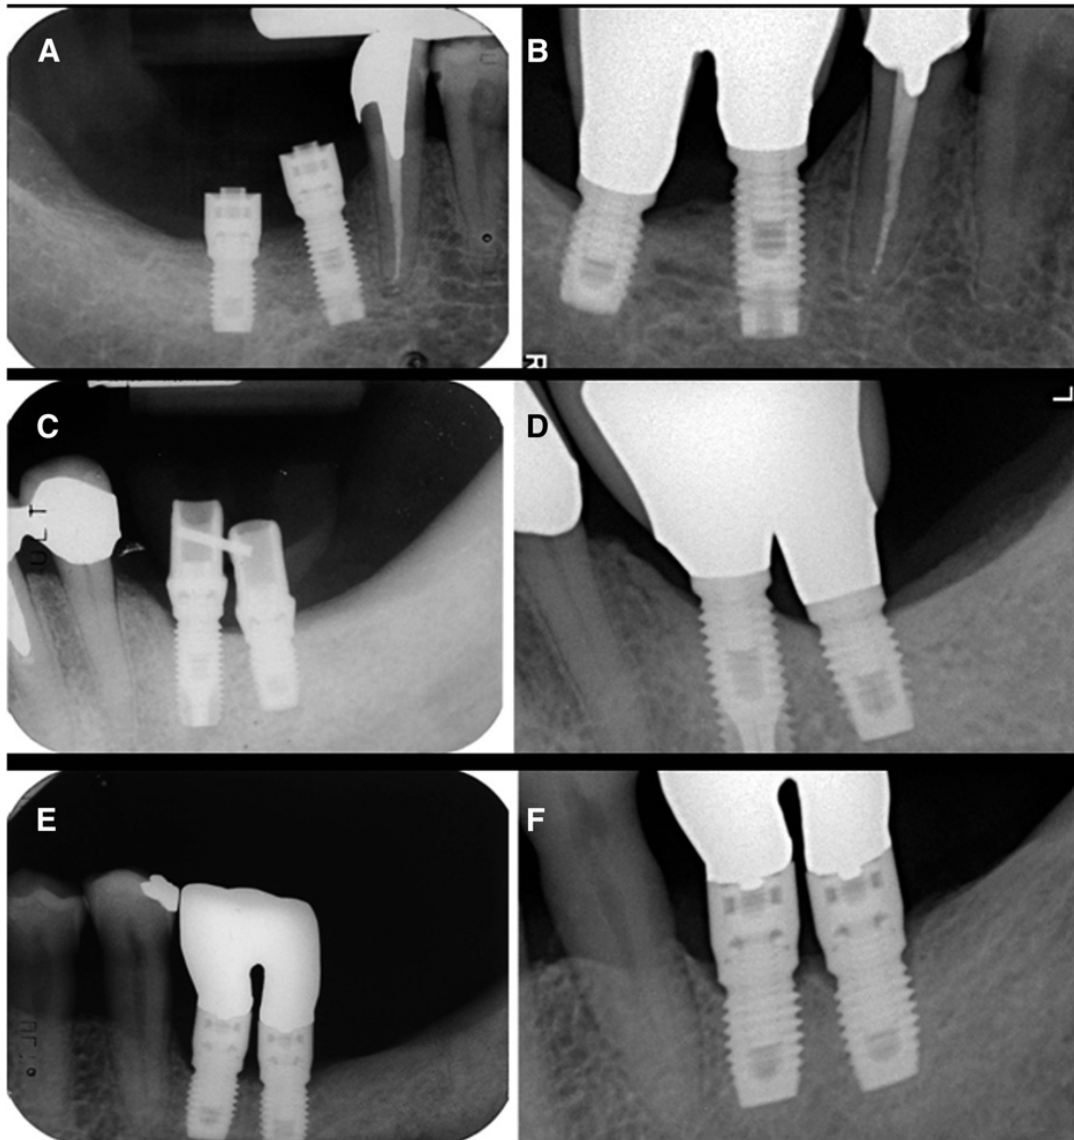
A and B) Standard M, threaded, 3.75 · 7–mm implant in site 31. A) Intraoral radiograph taken at time of loading (1997). B) Intraoral radiograph taken at the latest follow-up (2010). The short implant was splinted to a standard M, 3.75 · 10.5–mm implant (in site 30). C and D) Standard M, 4 · 7–mm implant in site 19. C) Intraoral radiograph taken at time of loading (1997). D) Intraoral radiograph taken at the latest follow-up (2008). The short implant was splinted to a 4 · 10–mm implant (site 18). E and F) Two standard M, 4 · 7–mm implants in sites 18 and 19. E) Radiograph taken at time of loading (1997). F) Radiograph taken at the latest follow-up (2008).
